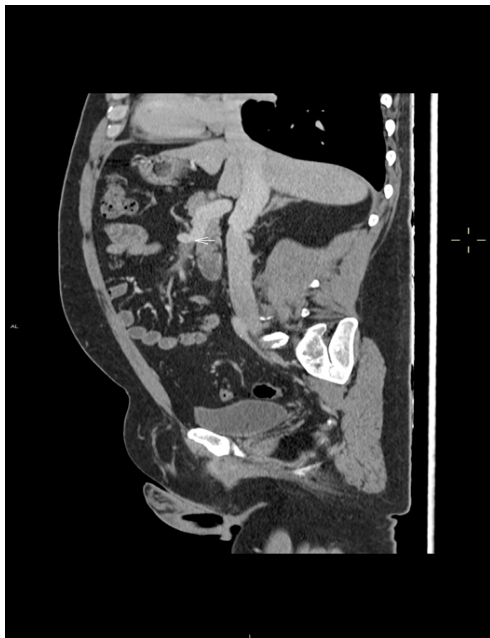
Oblique sagittal abdominal-pelvic CT image with i.v. contrast. in phase portal. There is a thrombosis of distal branches belonging to VMS (Arrow).
